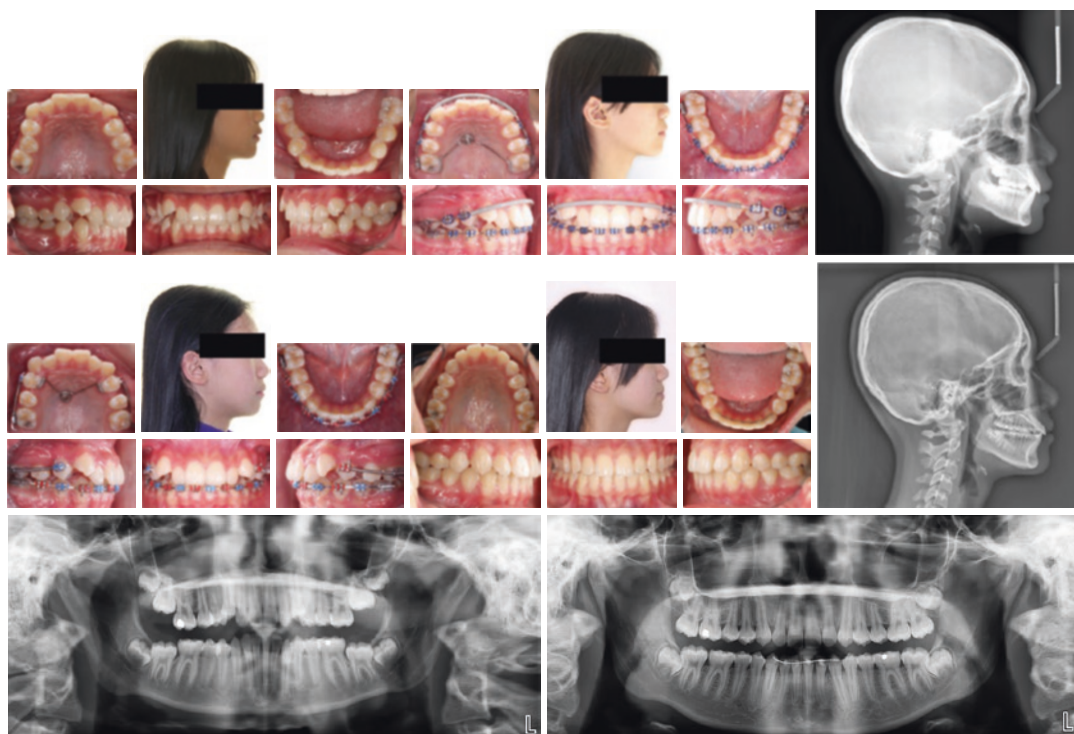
Pre- and post-treatment radiographs of a 15-year-old female who was treated with a Pendulum appliance. Post-treatment radiographs demonstrate the residual distal tip in the posterior teeth after the fixed
